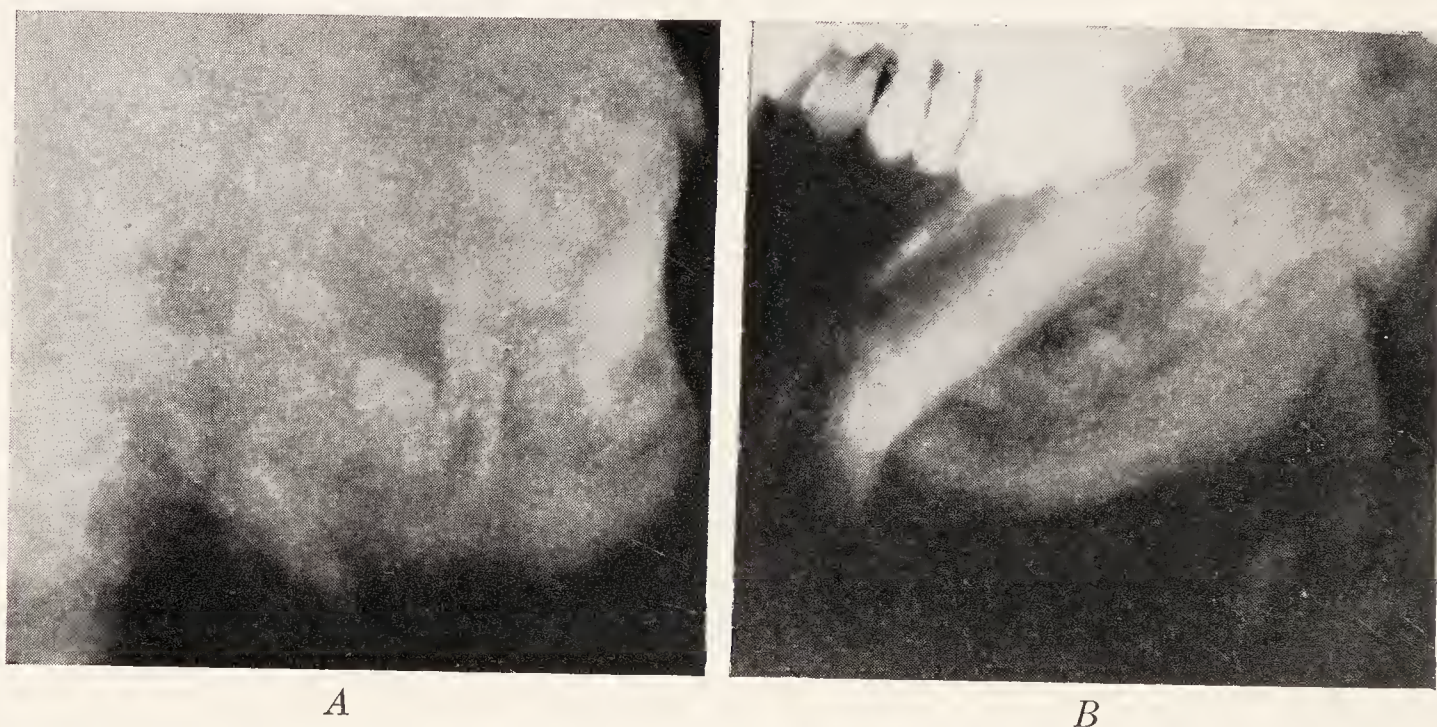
A*, Boy about thirteen years old with an osteomyelitis which shows a sequestrum of the ramus and in the body of the mandible. *B*, Osteomyelitis in a boy about fourteen years of age. He had already had his teeth removed when the roentgenogram was taken. He has a sequestration of the alveolar ridge and a part of the mandible.
